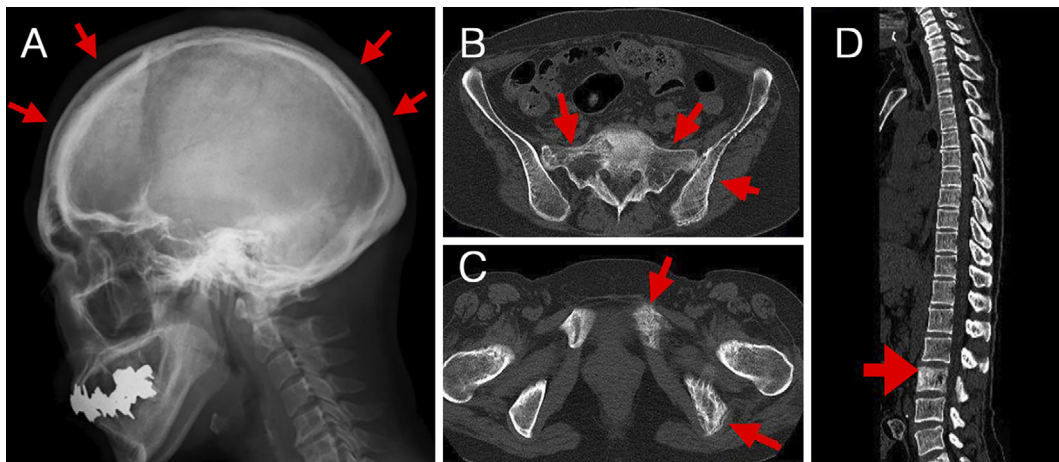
Pathological changes due to Paget's disease of bone on imaging examinations. Skull radiography revealed mild bone hypertrophy and thickening (A). On computed tomography, thickening of the bone cortex and increased endosteal resorption in the sacroiliac bone (B), ischiopubic (C), and 3rd lumbar vertebra (D) were observed.
